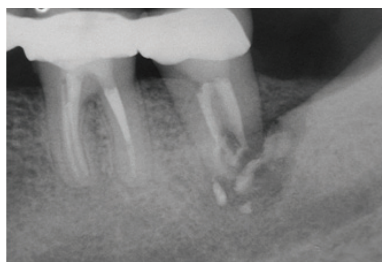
Radiograph after surgery
